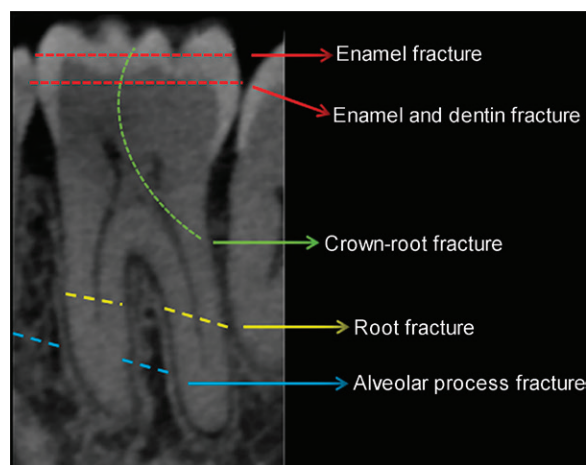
Dental fractures. Cone-beam CT image of a molar tooth shows lines representing different types of dental fractures.
